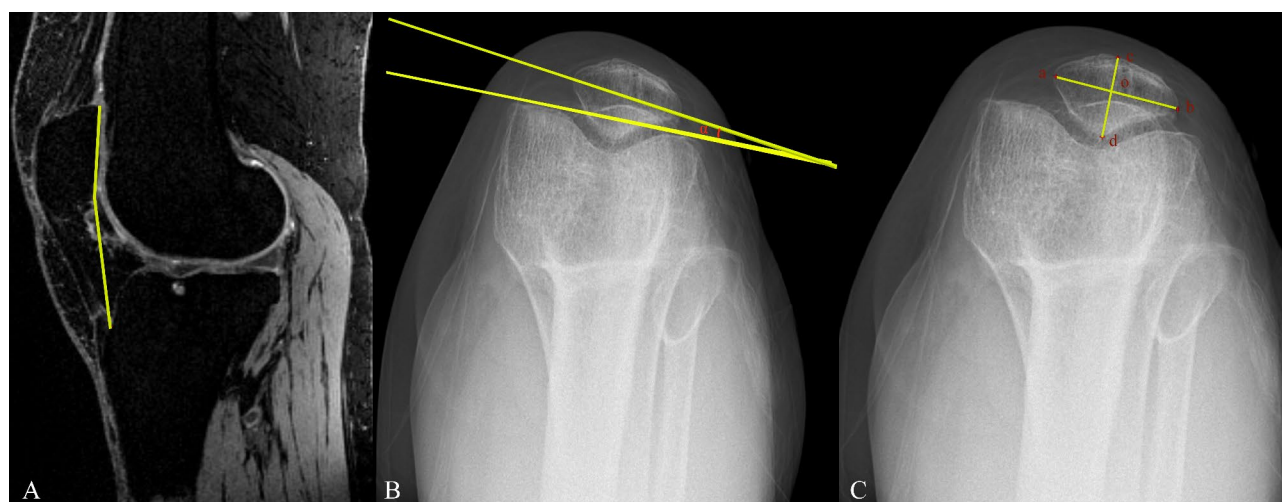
The alignment and morphology of the patella of measured radiograph. (A) Modified Insall Salvati ratio. It is the ratio of ratio of the distance between the distal pole of the patellar articular surface and the tibial tuberosity to the articular surface length of the patella. (B) Patellar tilt angle. It was defined as the angle subtended by the equatorial line of the patella and the line connecting the anterior limits of the femoral condyles. (C) Patella index. It was drawn by the two perpendicular lines (“ab” and “cd”), “ab” through the maximum width and “cd” through the maximum height of the patella, with their intersection point labelled “o.” Patella index was calculated as the ratio of (ab) to (bo-ao)
